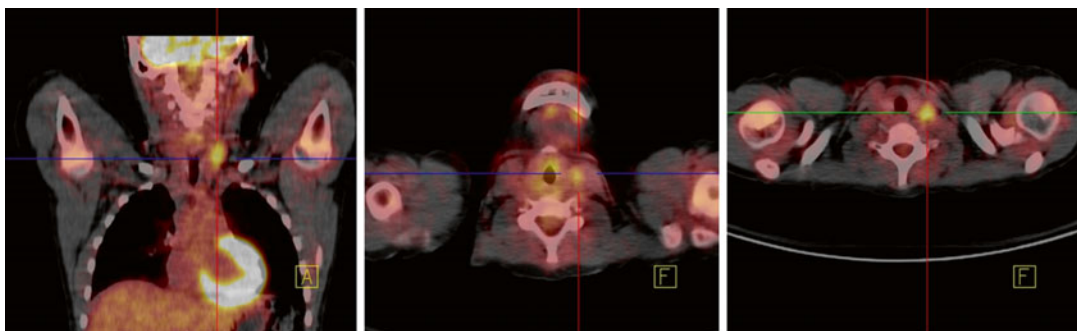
Fused PET/CT images: Hypermetabolic lesions at the neck and the supraclavicular area consistent with active disease
